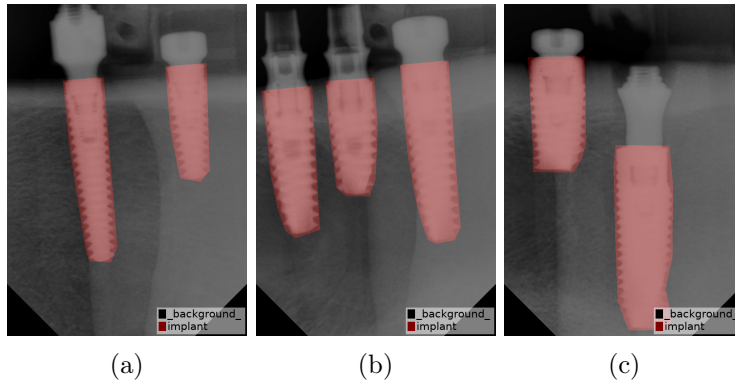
Examples of manually selected ROIs annotated using polygonal shapes, superimposed onto the actual X-ray images.
